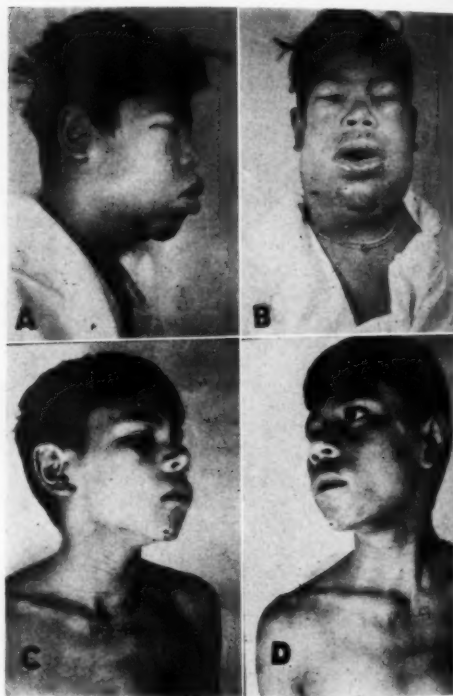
Case XII. A and B. Before roentgen treatment. C and D. Following treatment.
